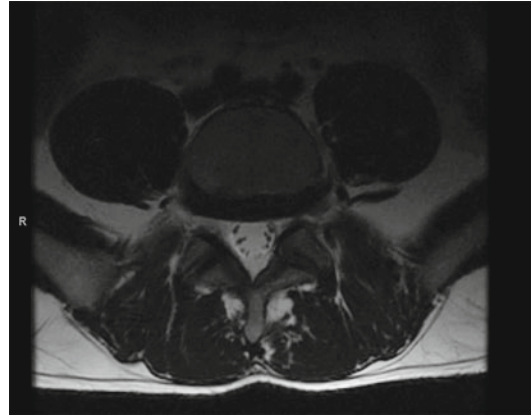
Axial cut of the T2 sequence of an MRI of the lumbar spine demonstrating the presence of a large, broad-based disc bulge at L5–S1 resulting in moderate left-sided foraminal stenosis
